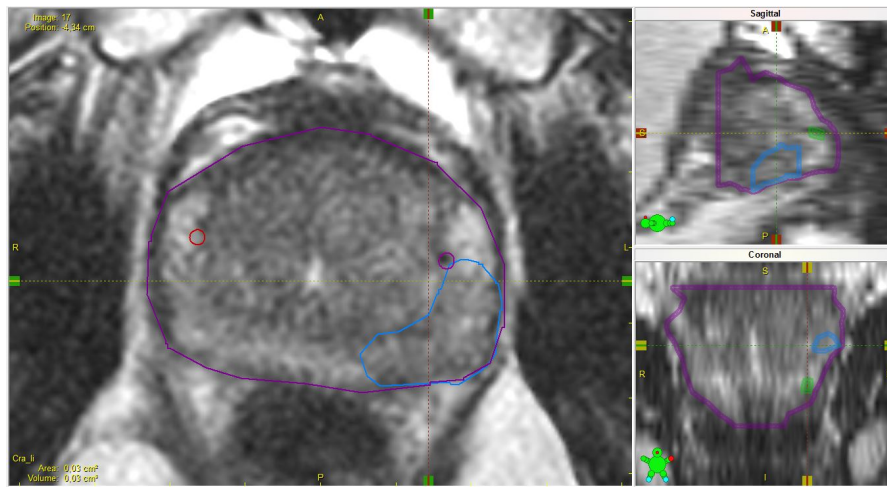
Ingetekende MRI studie van patient 8 in VariSeed. Prostate_{MRI} (paars), Boost₁ (lichtblauw) ingetekend op T2 en FMs (rood, magenta en groen) gelocaliseerd op T1. Image blending staat op T2.
